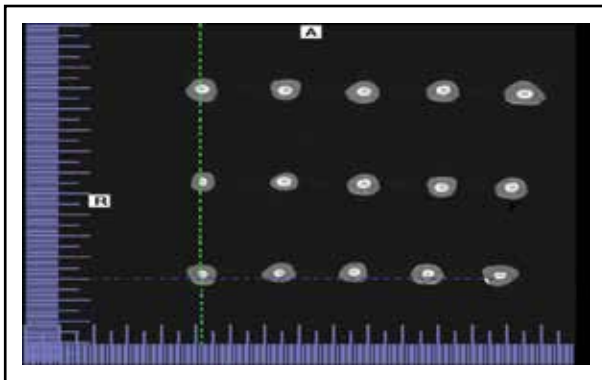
CBCT images of root canal filling with both conventional and zirconia enriched glass fiber posts at cervical and middle cross sections in axial plane
